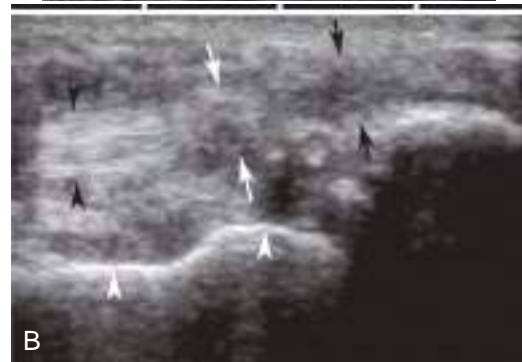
Complete tendon tears. (A) MR image of Achilles tendon rupture. Sagittal T2-weighted spin-echo image shows a complete tear at the musculotendinous junction of the Achilles. Note wide, fluid-filled gap due to retraction of the distal muscle fibers (arrows). (B) Ultrasonogram of complete tear of the posterior tibial tendon in the foot. Note normal tendon proximally (black arrowheads, at the left side of the image), but low echogenicity at the torn tendon margin (white arrows) and empty tendon sheath more distally (black arrows). Also note the medial cortex of talus (white arrowheads).
